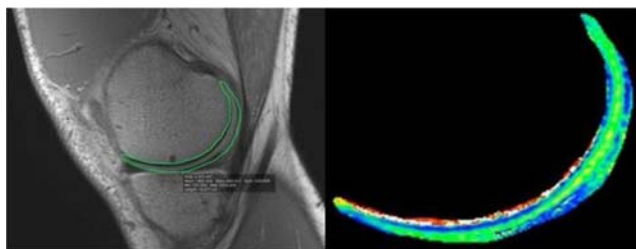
Biochemical status of normal cartilage tissue using MRI with T2-color mapping
